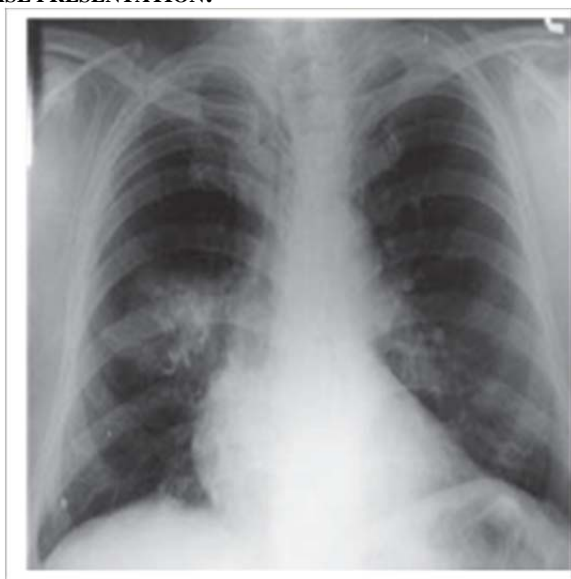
Chest X-ray shows the solitary pulmonary nodule in the right lung
